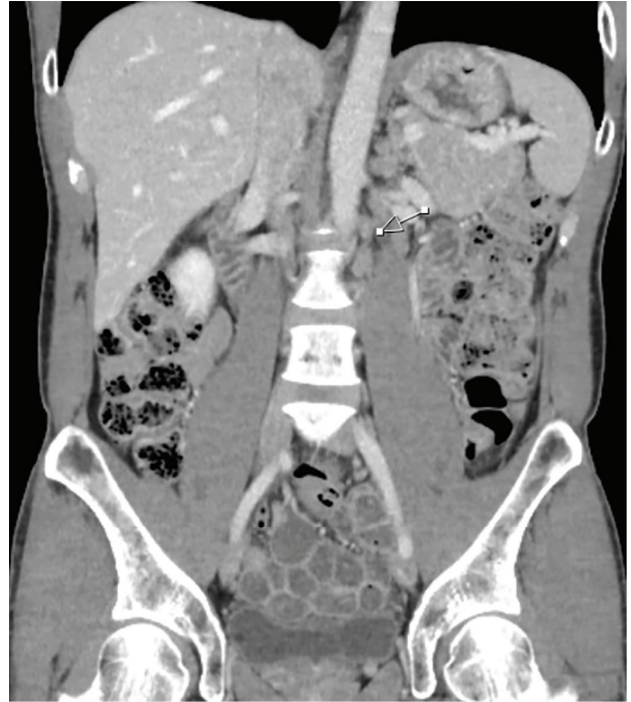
Coronal CT Abdomen and Pelvis Showing Several Foci of Periaortic Lymphadenopathy
